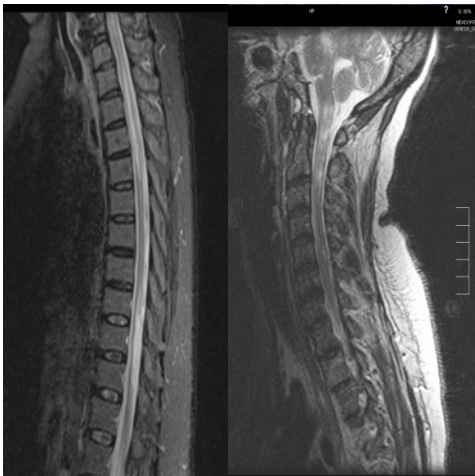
Fig. (2a) shows a T2 sagittal spine MRI of a 38 year-old woman who presented to our hospital with acute incomplete paraparesis displaying the typical LETM in acute NMO. Fig. (2b) shows a T2 sagittal spine MRI of a 51 year-old woman with chronic relapsing NMO showing the typical manifestations of chronic NMO including cord atrophy and patchy lesions.
